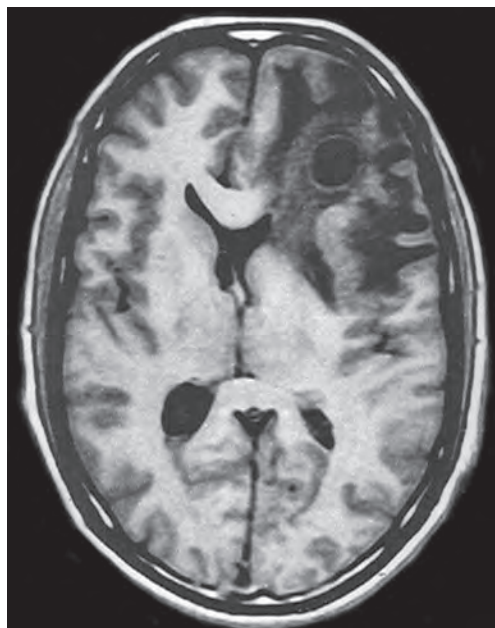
T1-weighted magnetic resonance showing left frontal abscess
